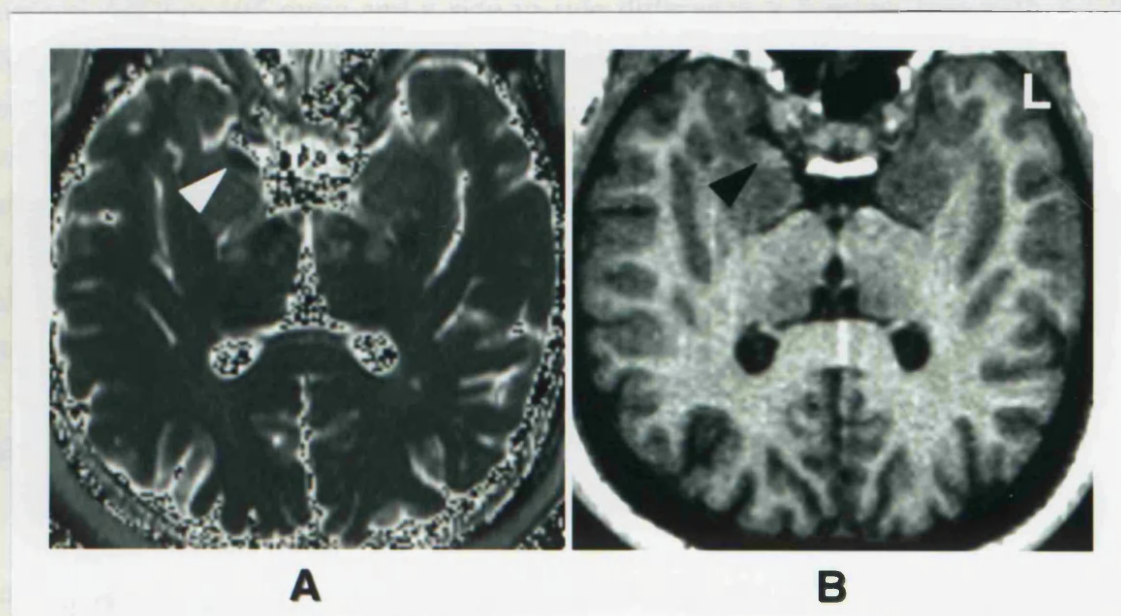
Isolated hypodense lesion of the amygdala. Patient was a 42 year old man with onset of TLE at the age of 9 years. There was no history of FCs, meningitis or cerebral trauma. A typical aura was characterized by a déjà vu, fear, an epigastric rising sensation, gustatory and olfactory hallucinations, and an experiential sensation that time went by 4 times as fast as usual. A CPS was characterized by unresponsiveness, oral automatisms and automatisms of the right arm and hand. He had an average of three CPS per week and never had a SGS. Interictal EEG showed a right antero-temporal epileptic focus, and ictal EEG showed bilateral discharges for the first ten seconds followed by right antero-temporal rhythmic theta waves. A standard MRI was normal and hippocampal quantitation was normal: HCT2 right = 105 msec, HCT2 left = 99 msec (NI: ≤ 108 msec), HCVR (L/R)= 0.95 (NI: ≥ 0.87), HCV right = 5321 mm^3 , HCV left = 5049 mm^3 (NI: $\geq 4348 \text{ mm}^3$). The AT2 map (A) showed a hypodense lesion (white arrow) in the right amygdala near the uncinate gyrus. The AT2 as defined for this study was normal in both amygdalae, on the right 100 msec and on the left 98 msec. However, the T2 measured with a ROI which fitted this hypodense lesion was 70 msec. This lesion was also visible as an intra-axial hyperdense lesion (black arrow) on a 1 mm thick T1-weighted section of the reformatted MPRAGE dataset (B), which was used to determine the coordinates of the AT2 map. The patient underwent an anterior temporal lobe resection with amygdectomy and minimal hippocampal resection. Neuropathological examination of the resected amygdala showed a small DNET. Patient has remained seizure free after surgery. [Hospital number: QSB18240].
